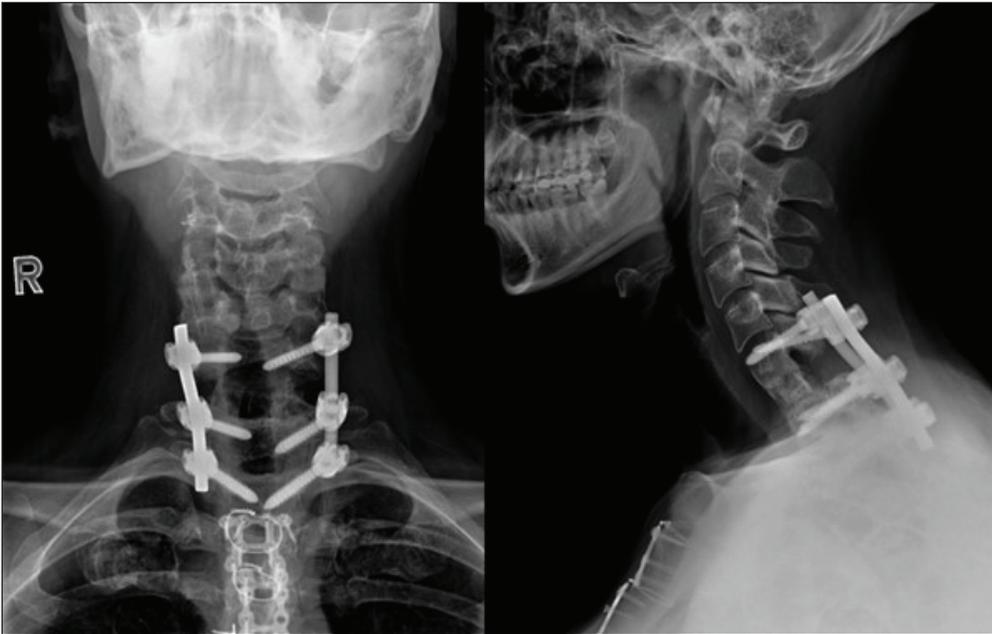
Postoperative 6 month X-ray AP/lateral view in patient 1.
